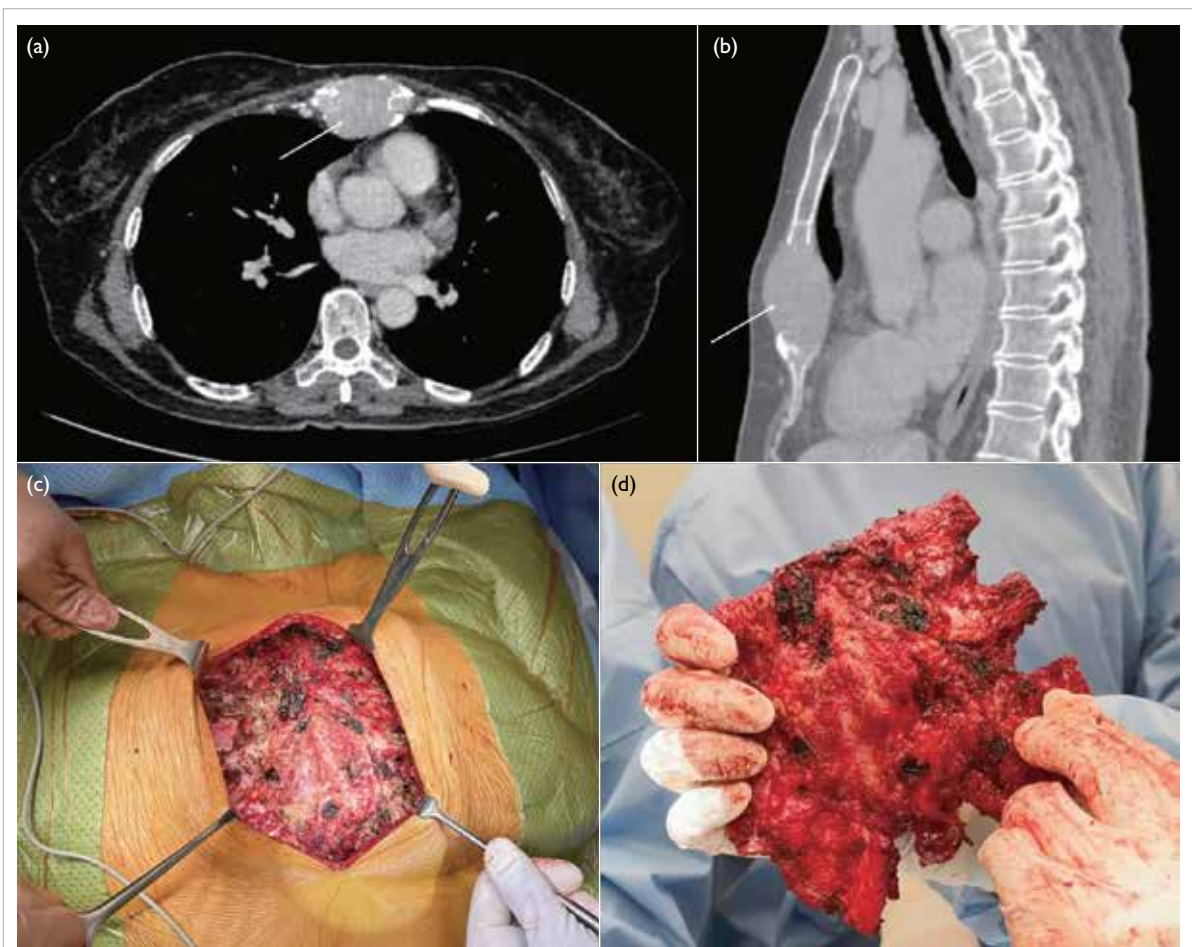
Sternal metastasis from follicular thyroid carcinoma. (a) Axial and (b) sagittal cuts of computed tomography images showing the lower sternal metastasis (arrows). (c) Intra-operative photo before resection. (d) En bloc resected sternal metastasis with part of adjacent ribs
